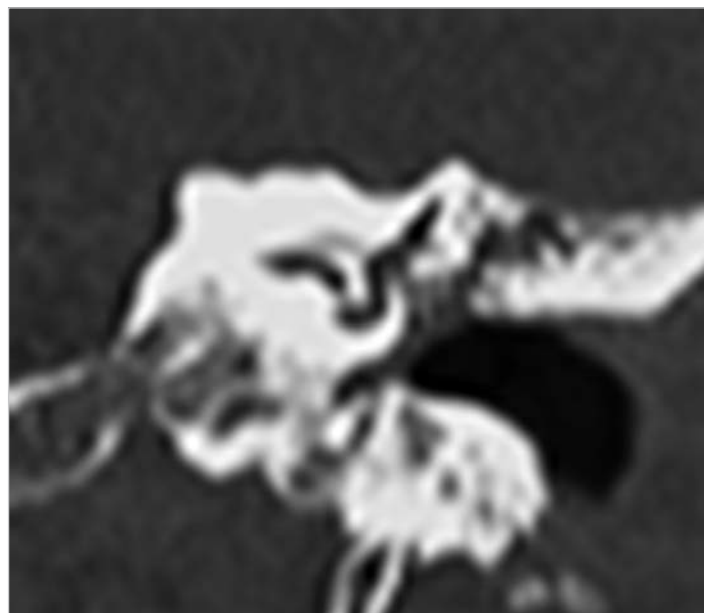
CT scan of the same case, coronal view. The long process of the incus and stapes superstructure are eroded by the cholesteatoma.
